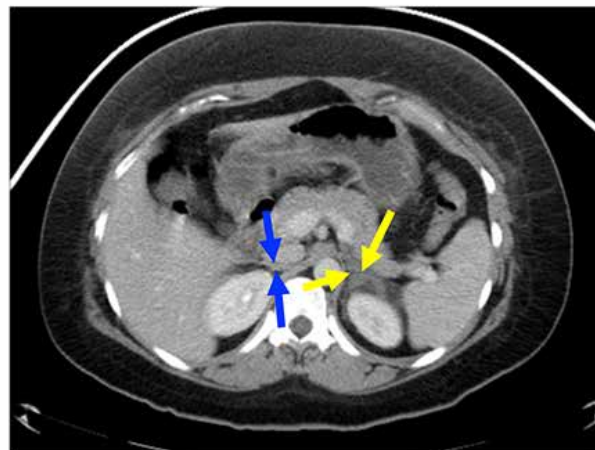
Cross-sectional abdominal CT scan with thickening and stranding (yellow arrows) surrounding the left adrenal gland consistent with adrenal hemorrhage. Normal right adrenal gland (blue arrows)
